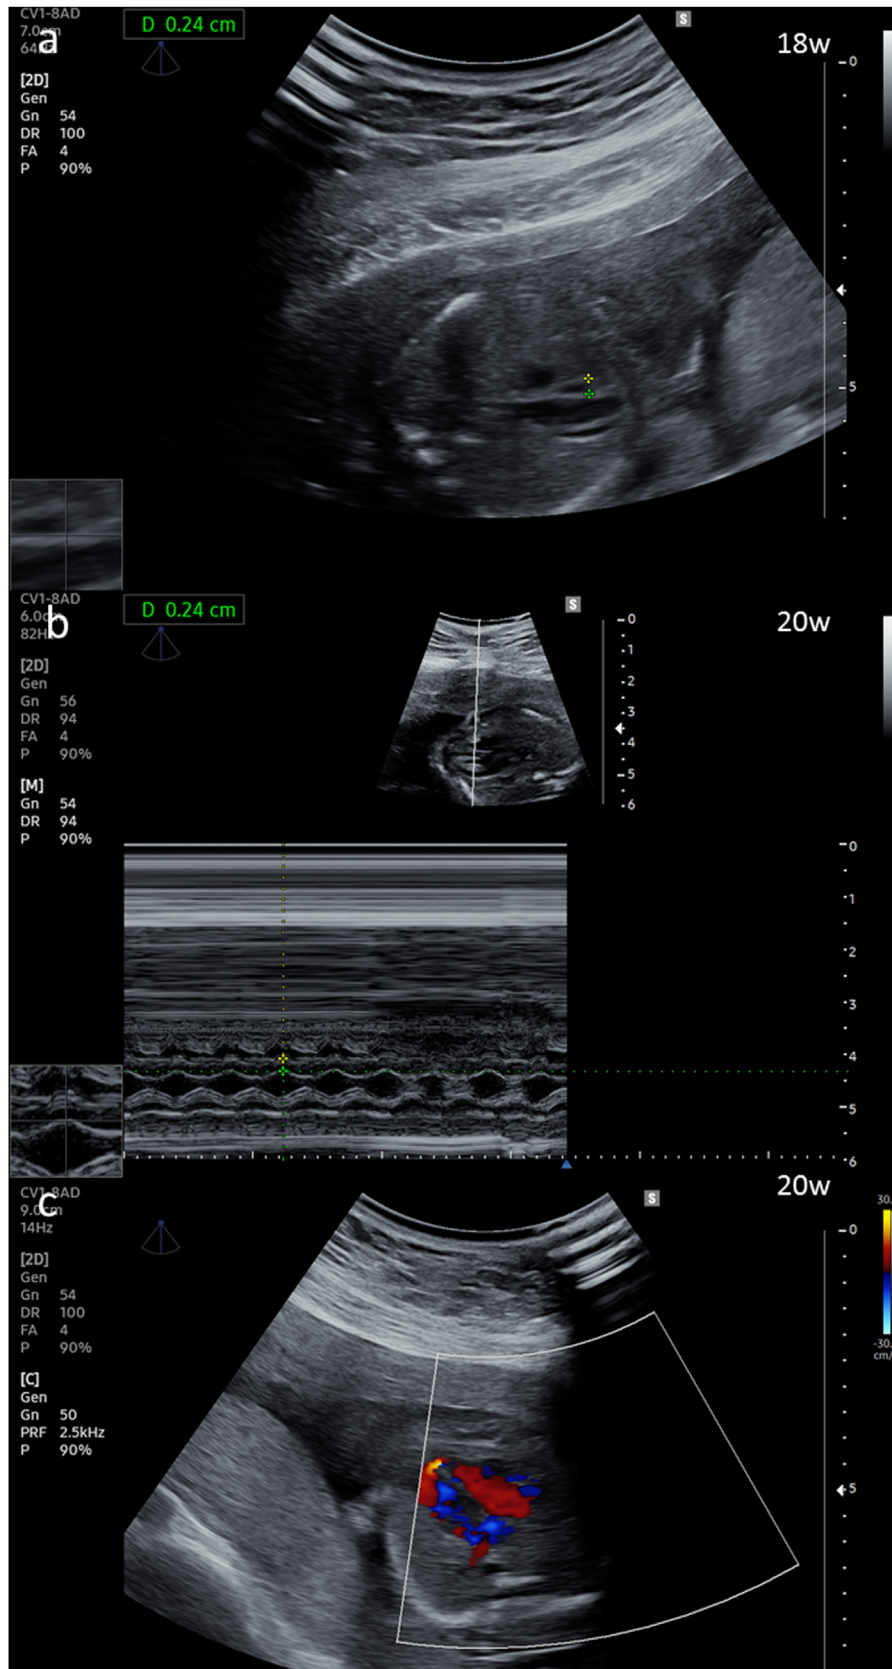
Prenatal echocardiography. a. Two-dimensional measurement of interventricular septum at 18 w. b. M-mode measurement of interventricular septum at 20 w. c. Small apical ventricular septal defect detected at 20 w.
